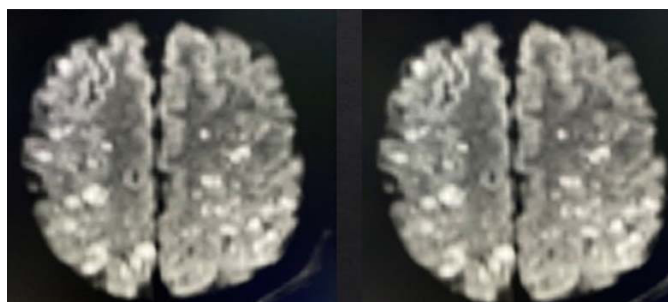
Magnetic resonance imaging (MRI) in diffusion (DWI) showing multifocal lesions affecting the core-capsular regions and the thalamus bilaterally, characterizing the “stellar field” pattern (field/starry sky). Source: Hospital Santa Isabel.
